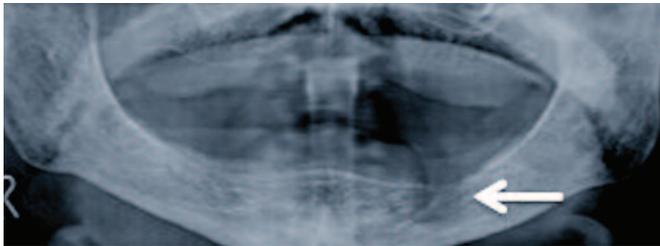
Orthopantomogram of the patient demonstrating an abnormality in the left body of the mandible (arrowhead).
